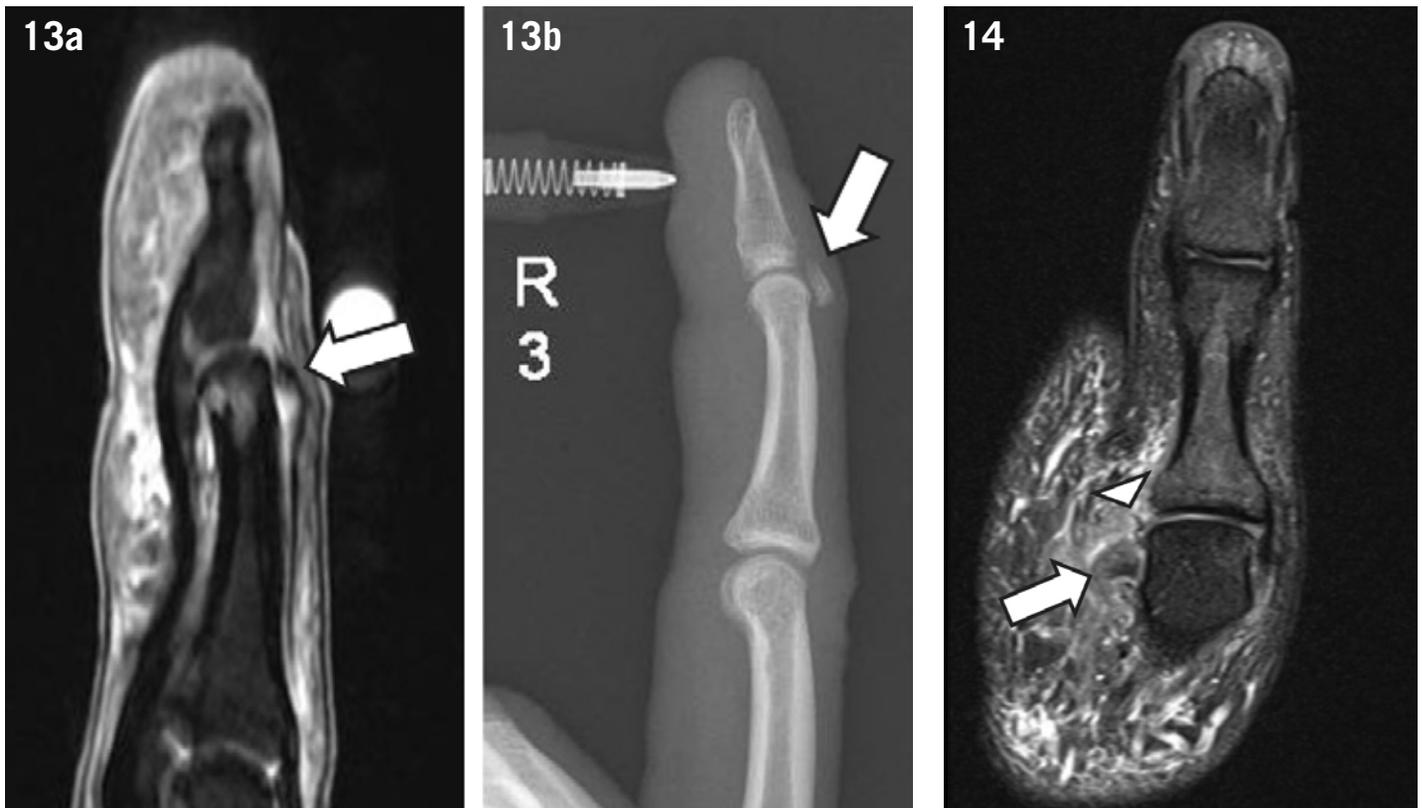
Magnetic resonance imaging and radiography of a mallet finger. Sagittal T2 weighted image (a) and radiography - lateral view (b) depict an avulsion of the terminal tendon of the extensor mechanism (arrow in a) with an osseous fragment from the dorsal aspect of the base of the distal phalanx, easily identified in the radiograph (arrow in b).
